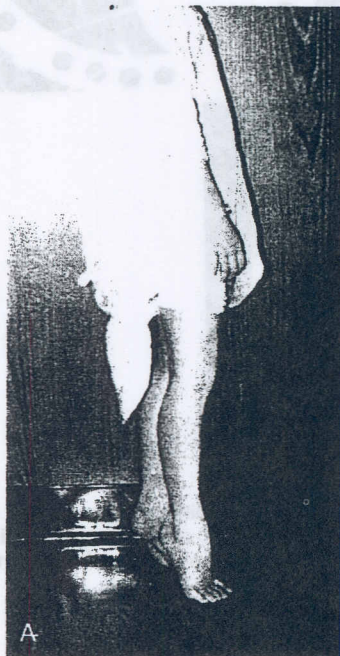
(A), A boy with a bilateral equinovarus foot deformity of congenital origin. (B), The apparatus was applied for the correction of the hindfoot equinus, followed by correction of the forefoot cavus. (C), The lateral radiograph during treatment. (A to C courtesy of Dror Paley, M.D.)
